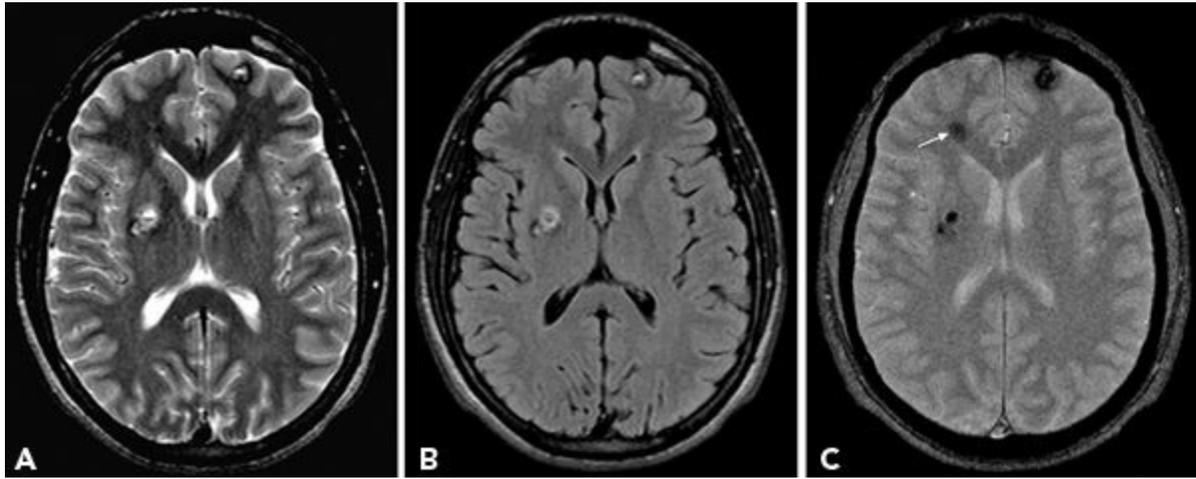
Axial T2-weighted (A), FLAIR (B), and gradient-echo images (C) show multiple cavernomas. Gradient-echo sequence reveals additional lesion in right frontal region (arrow) that is inconspicuous on T2 and FLAIR images.
